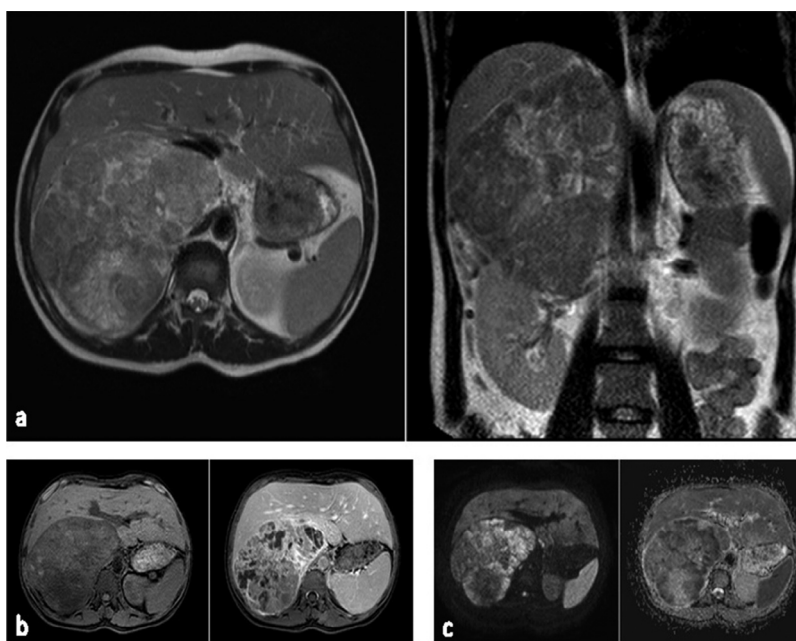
(A) Axial and coronal T2-weighted images show a large right adrenal mass partially displacing the liver. The mass has heterogeneous areas of low and high signal intensities, suggestive of solid and necrotic areas. (B) Precontrast and postcontrast fat-saturated T1-weighted images show heterogeneous areas of contrast enhancement. (C) Diffusion-weighted imaging shows that the solid areas restrict diffusion, consistent with high cellularity. The corresponding apparent diffusion coefficient image shows these areas as hypointense, confirming the restriction of diffusion.
